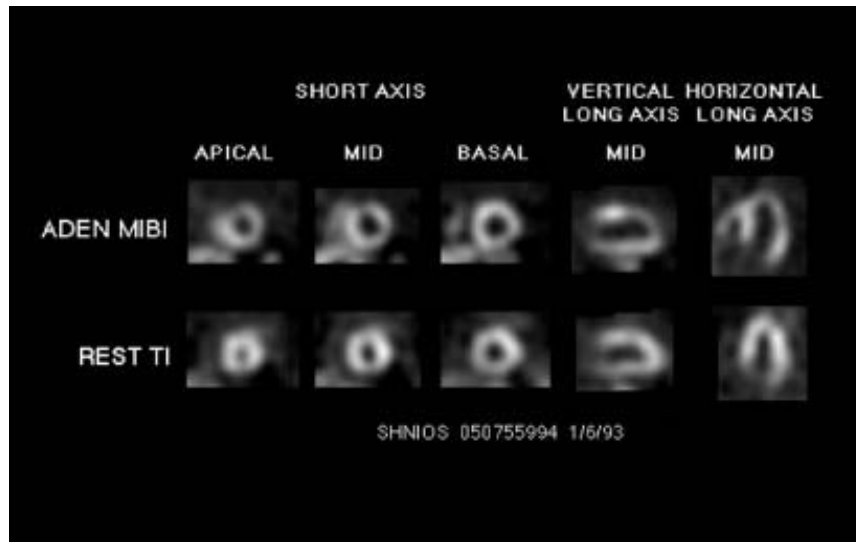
Normal rest ^{201}Tl SPECT (*bottom*) followed by adenosine $^{99\text{m}}\text{Tc}$ sestamibi (ADEN MIBI) (*top*) in a patient with intermittent chest pain which had resolved prior to injection with ^{201}Tl at rest. Reversible defects are seen in the left anterior descending and left circumflex territories. Angiography revealed 50 percent left main, 100 percent left anterior descending, 90 percent left circumflex, and 50 percent right coronary artery stenoses.
